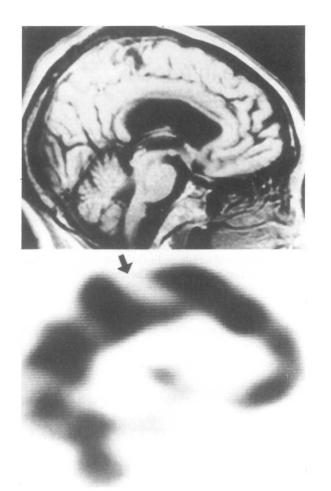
A focal infarction in the left paracentral lobule can be seen on a magnetic resonance T1 weighted image (top). A sagittal image of single photon emission CT (bottom) revealed a corresponding reduced uptake of the tracer (arrow).
